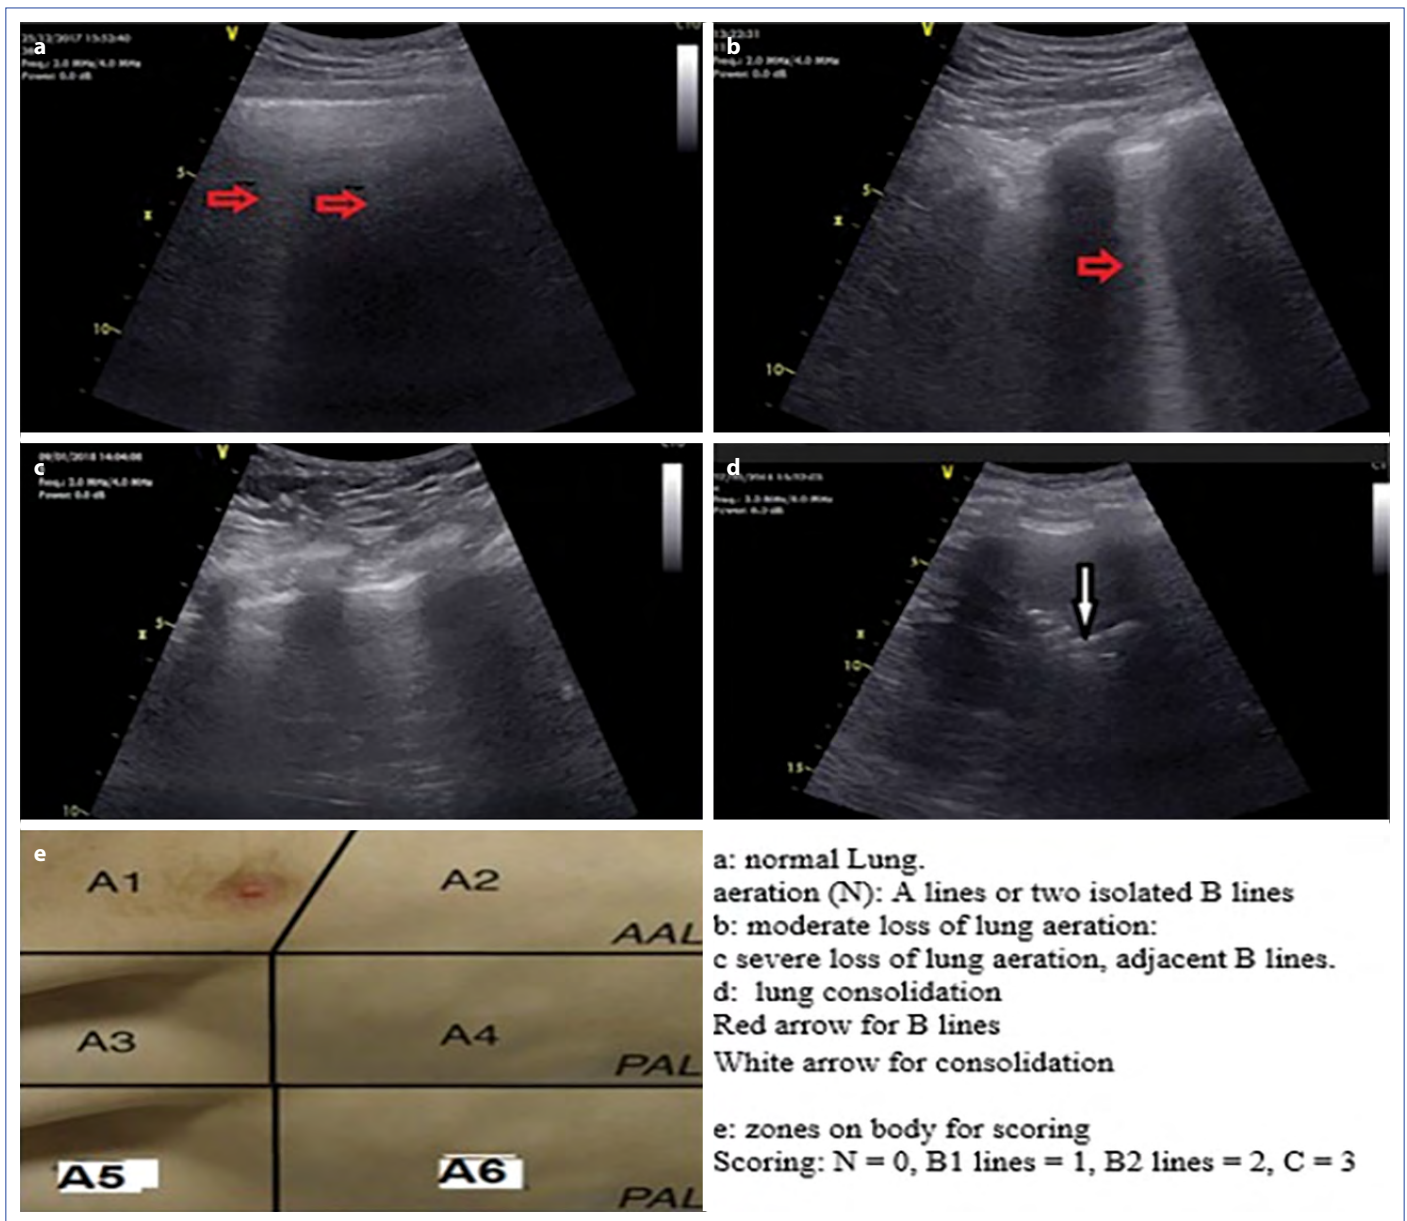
Four different ultrasounds examples from normal lung to lung consolidation for calculating lung ultrasound score, and sample areas for scoring. (a) Normal lung; (b) Moderate loss of lung aeration, (c) Severe loss of lung aeration, (d) Lung consolidation, (e) Zones on chest and scoring.
